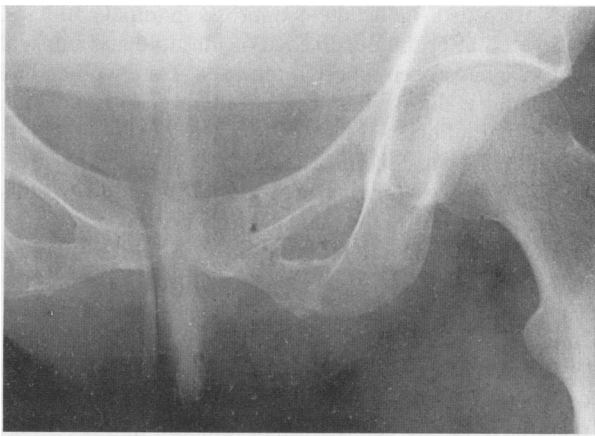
The detail of an anteroposterior radiograph of the pelvis shows a left superior pubic ramus fracture with a vacuum phenomenon.
